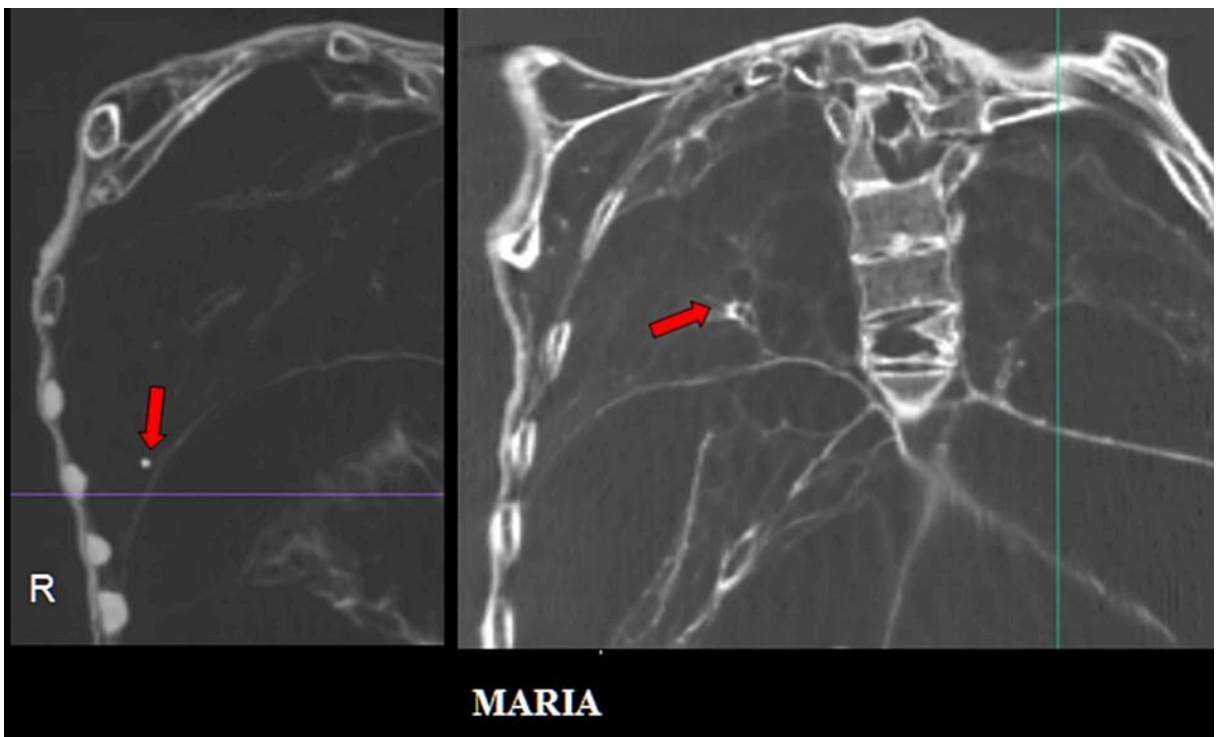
2D sagittal (*left*) and coronal (*right*) CT scans showing tiny calcified foci (*red arrows*) and small fibrotic scarrings in both lungs.
